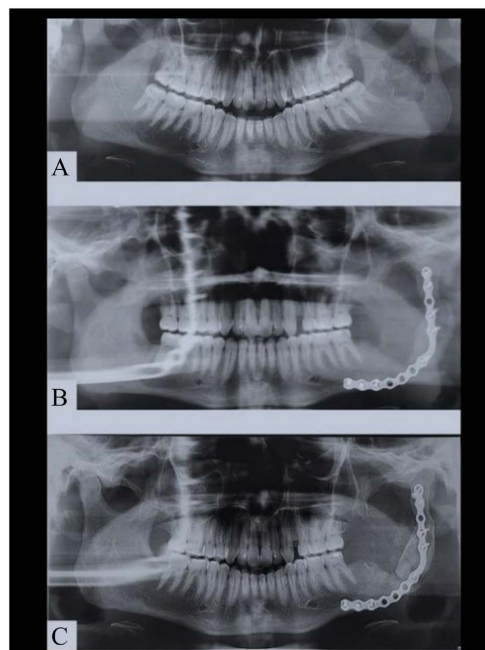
(A) Preoperative orthopantomogram; (B) 6 months postoperative orthopantomogram; (C) 2 years Postoperative orthopantomogram.
